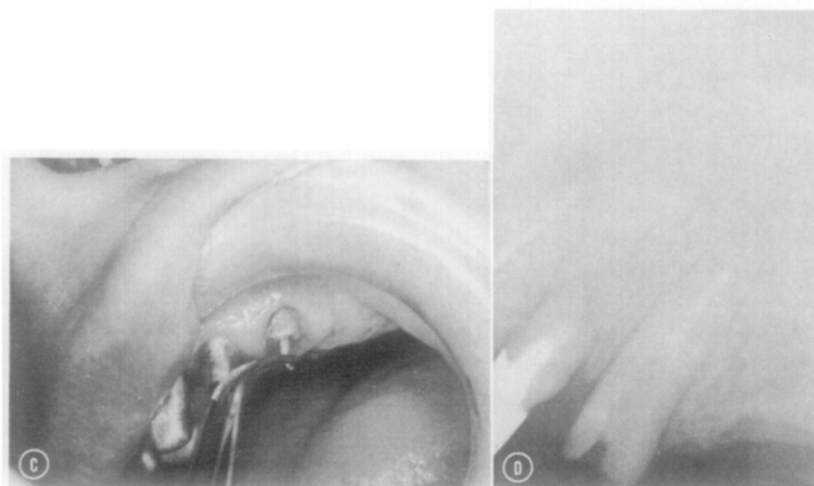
C, Dislodged post removed with pliers. D, Radiograph shows that post is removed.
